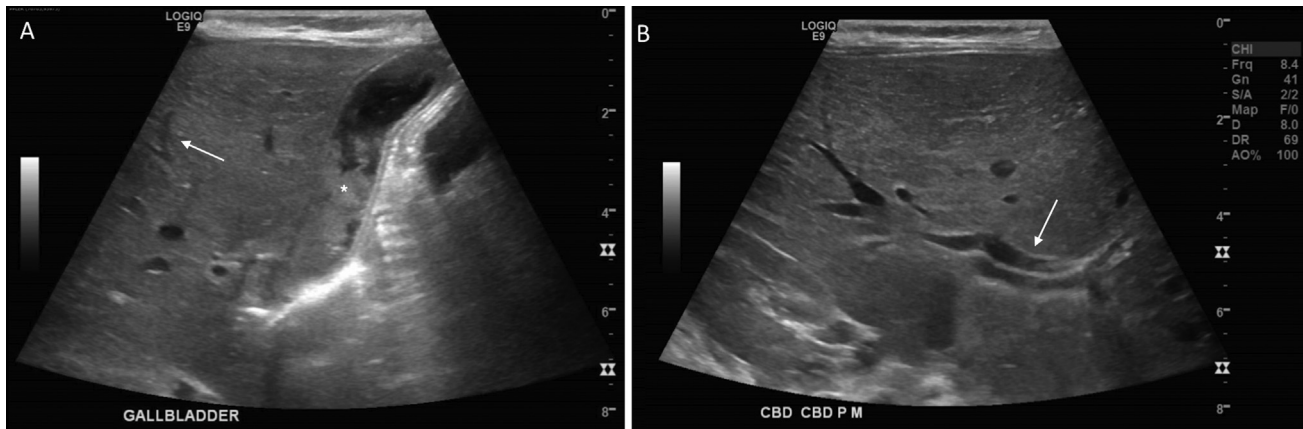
Initial right upper quadrant ultrasound showing distended gallbladder with biliary sludge(*) (A) and dilated intra- (arrow) and extrahepatic (arrow) bile ducts (B). CBD, common bile duct.
